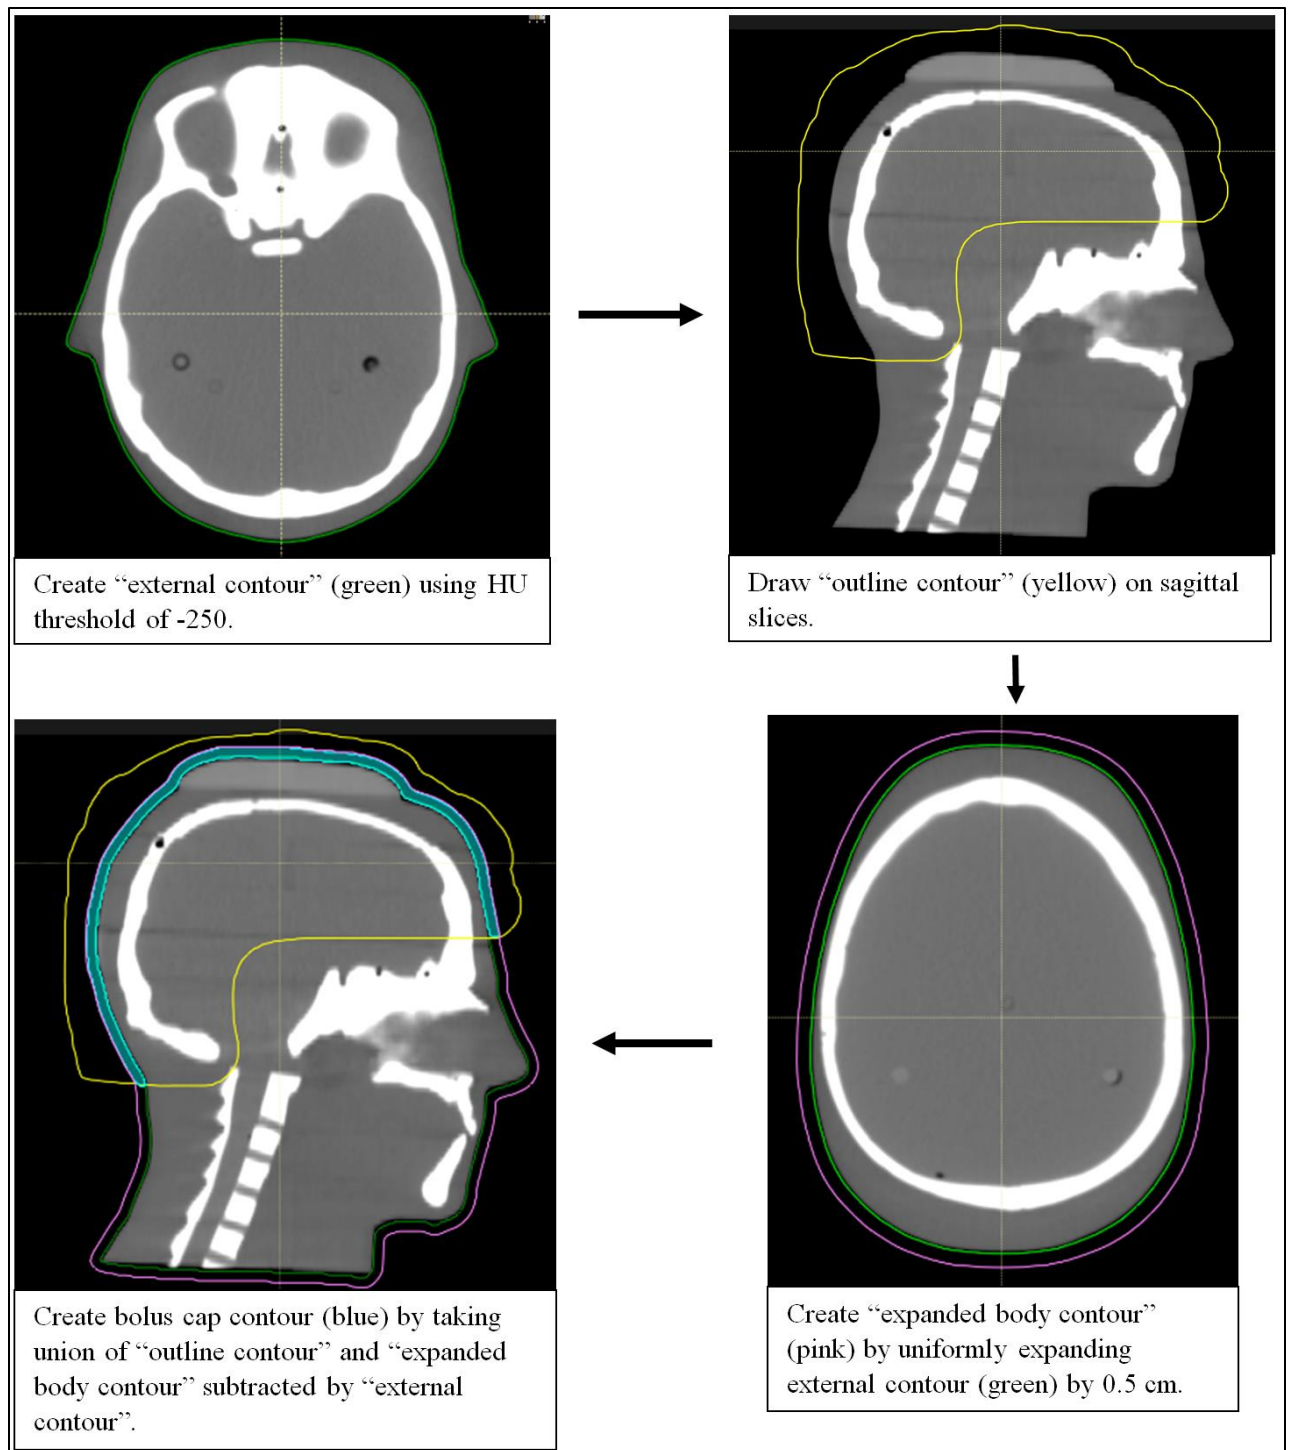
Process for creating a bolus cap contour from a CT scan in RayStation.
